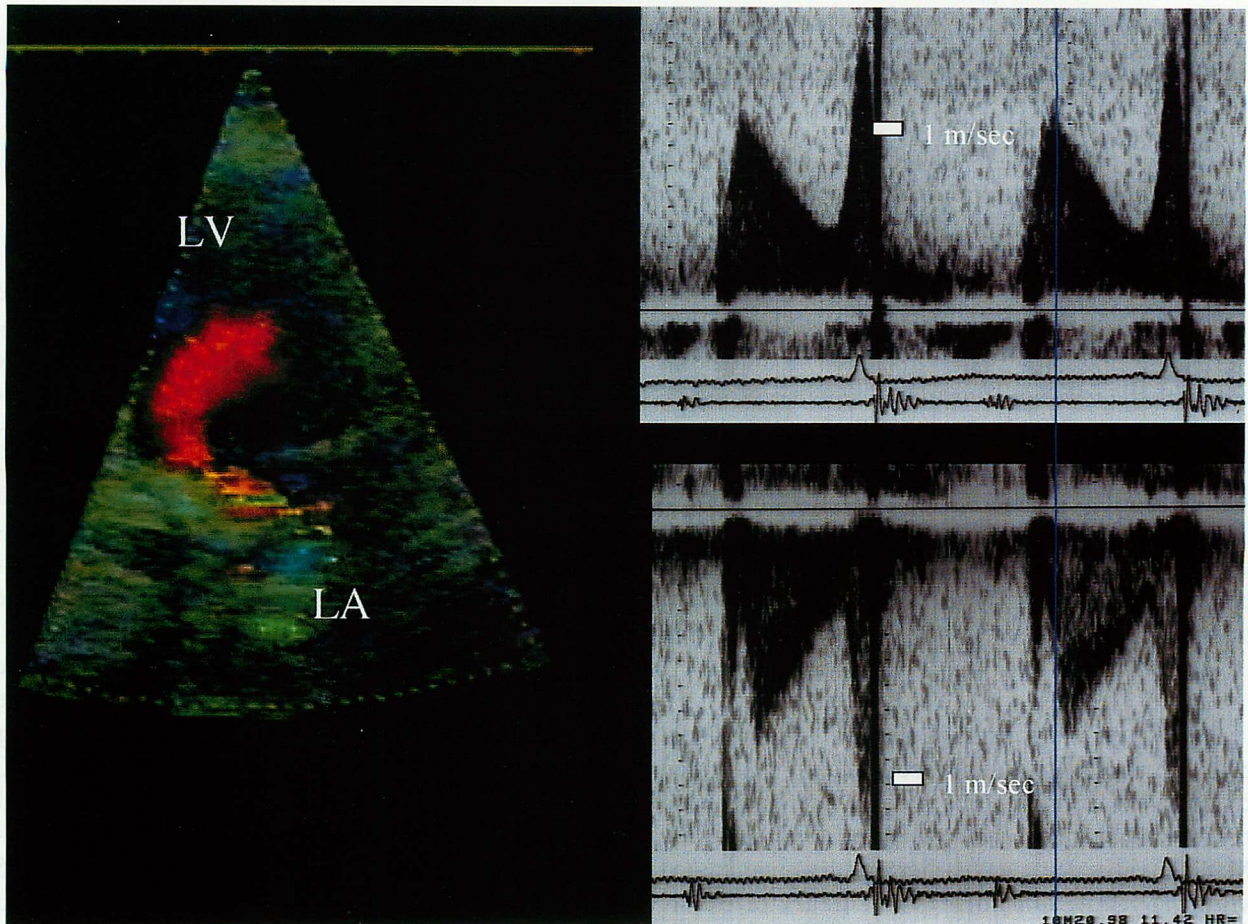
Color echocardiogram showing an abnormal color flow signal in diastole from the prosthetic valve extending to the left atrium (left), and pulsed Doppler echocardiograms demonstrating a mirror image signal (right lower) almost identical to the left ventricular inflow (right upper) except for the direction
